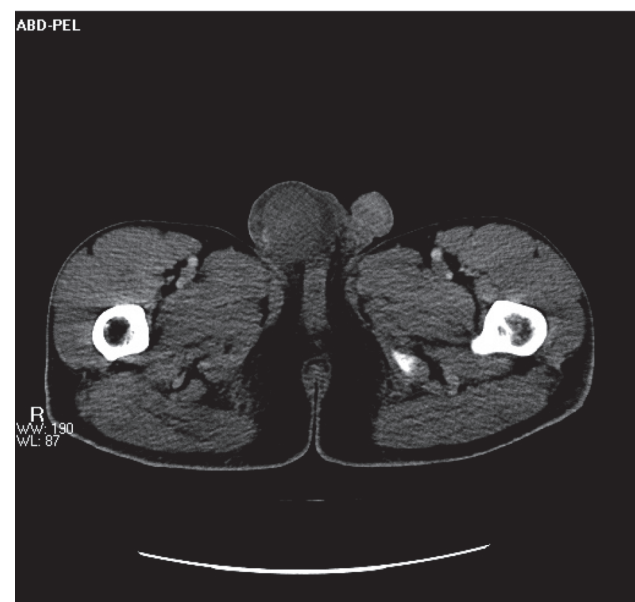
Computed tomography scan (CT scan) shows a heterogeneous 4-6 cm scrotal mass near the right testes.
